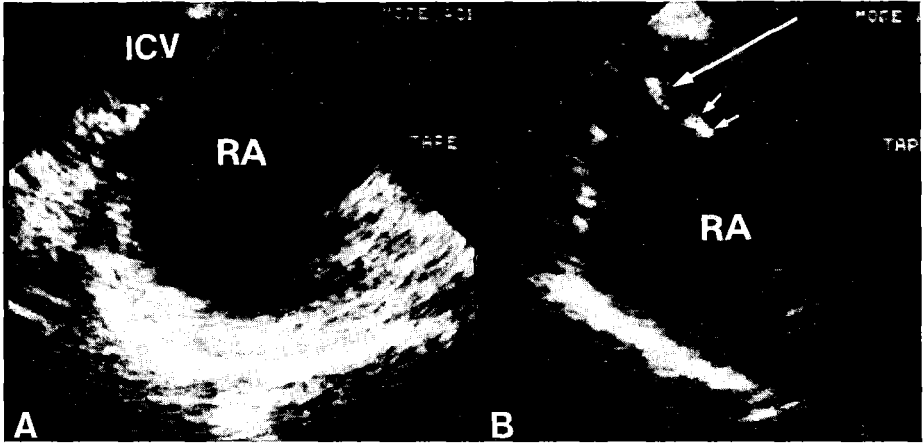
Esophageal echocardiograms obtained in a normal individual (A) and a patient (B) with a mass lesion (arrows) attached to the inferior caval vein (ICV). RA = right atrium.
